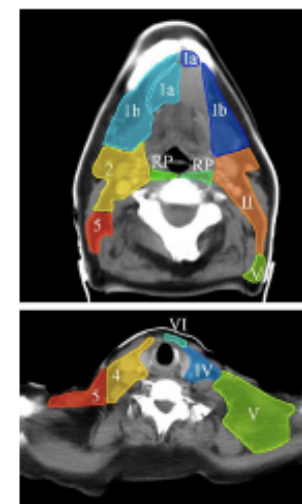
Comparison between the simplified Rotterdam guideline (left side of the neck, Arrows figure) and the Iltis guideline (right side of the neck, Arrows figure) for the delineation of the neck node levels. On the top, CT slice at the level of the hyoid bone of the mandible, with 1a, 1b, 2 and 3, and retropharyngeal nodes (RP) are displayed. On the bottom, CT slice at the level of the carotid sheath, levels IV, V and VI are displayed.
